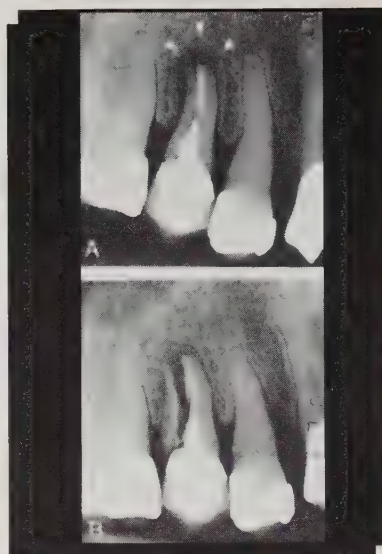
Periapical radiographs of a post-reconstructed maxillary premolar. The halo-like radiolucency at the apex is characteristic of vertical root fractures (A). A delay in treatment occurred, and the radiograph taken four months later revealed complete separation of root segments (B).
